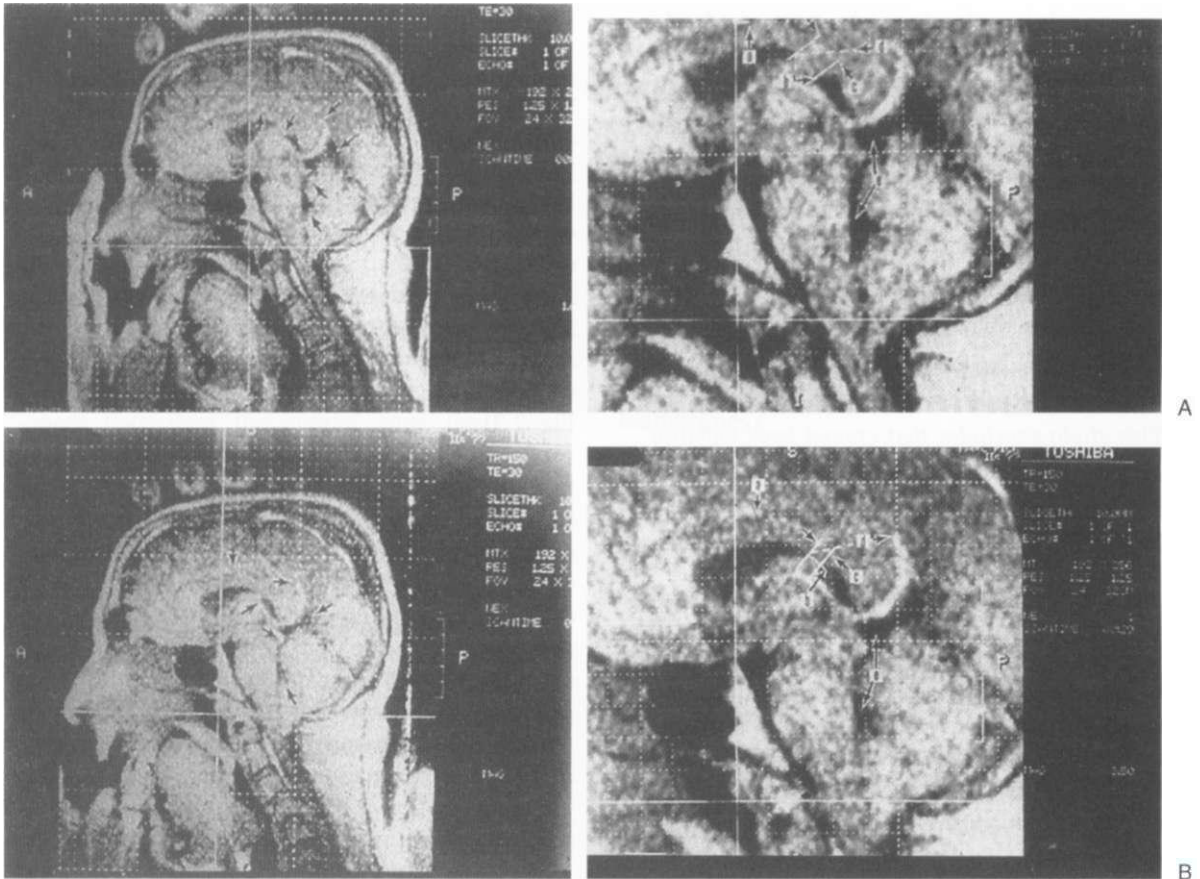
Mid-sagittal MRI scan of an adult human brain (A) before and (B) after cranial manipulation. Black arrows indicate where corpus callosum (a), lateral ventricle (b), fornix column and fourth ventricle (e) (picture B on the right side) show clear signs of tissue movement. (Reprinted from *Journal of Manipulative and Physiological Therapeutics*, 17, Pick M, A preliminary single case magnetic resonance imaging investigation into maxillary frontal-parietal manipulation and its short term effect upon the intracranial structures of an adult human brain, pp 168-173, copyright 1994, with permission from 'The National University of Health Sciences'.)
